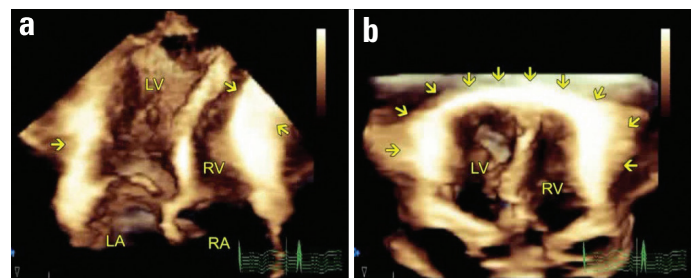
Three-dimensional (3-D) transthoracic imaging. The extent of pericardial calcification was better observed on three-dimensional echocardiograms. (a) The 3-D dataset was cropped to show the calcified pericardium next to the right ventricular (RV) free wall, causing a mild narrowing of the RV inflow; (b) the calcified pericardium surrounding both the ventricles were shown after cropping the 3-D dataset. Note the relative sparing of the anterior wall on the 3-D image
